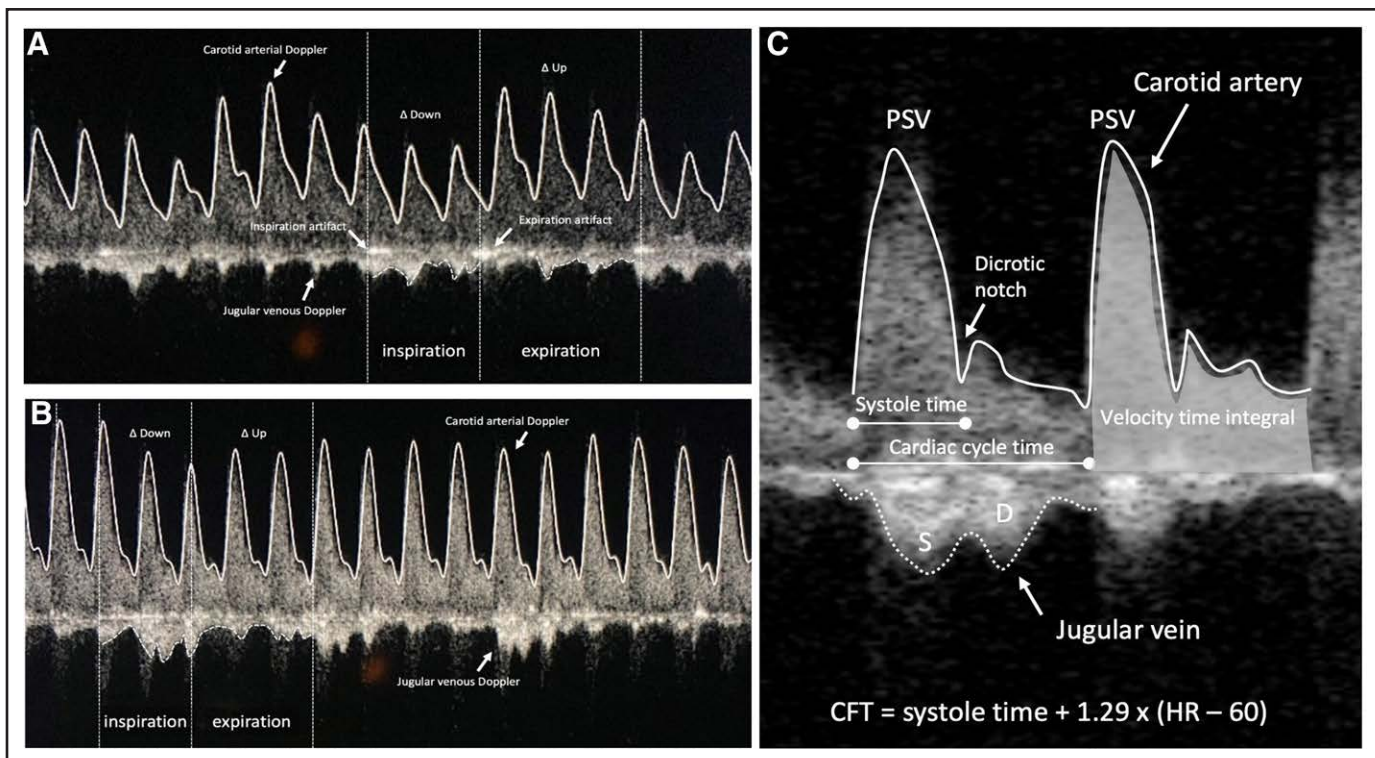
Carotid Doppler tracings before (A) and after (B) pericardiocentesis with associated changes in corrected carotid flow time (CFT) (277–326 ms; +15% change), peak systolic velocity (PSV) variation (45–8%; –37% change), velocity time integral variation (VTI) (52–17%; –35% change), and corrected carotid flow time variability (37–20%; –17% change).
